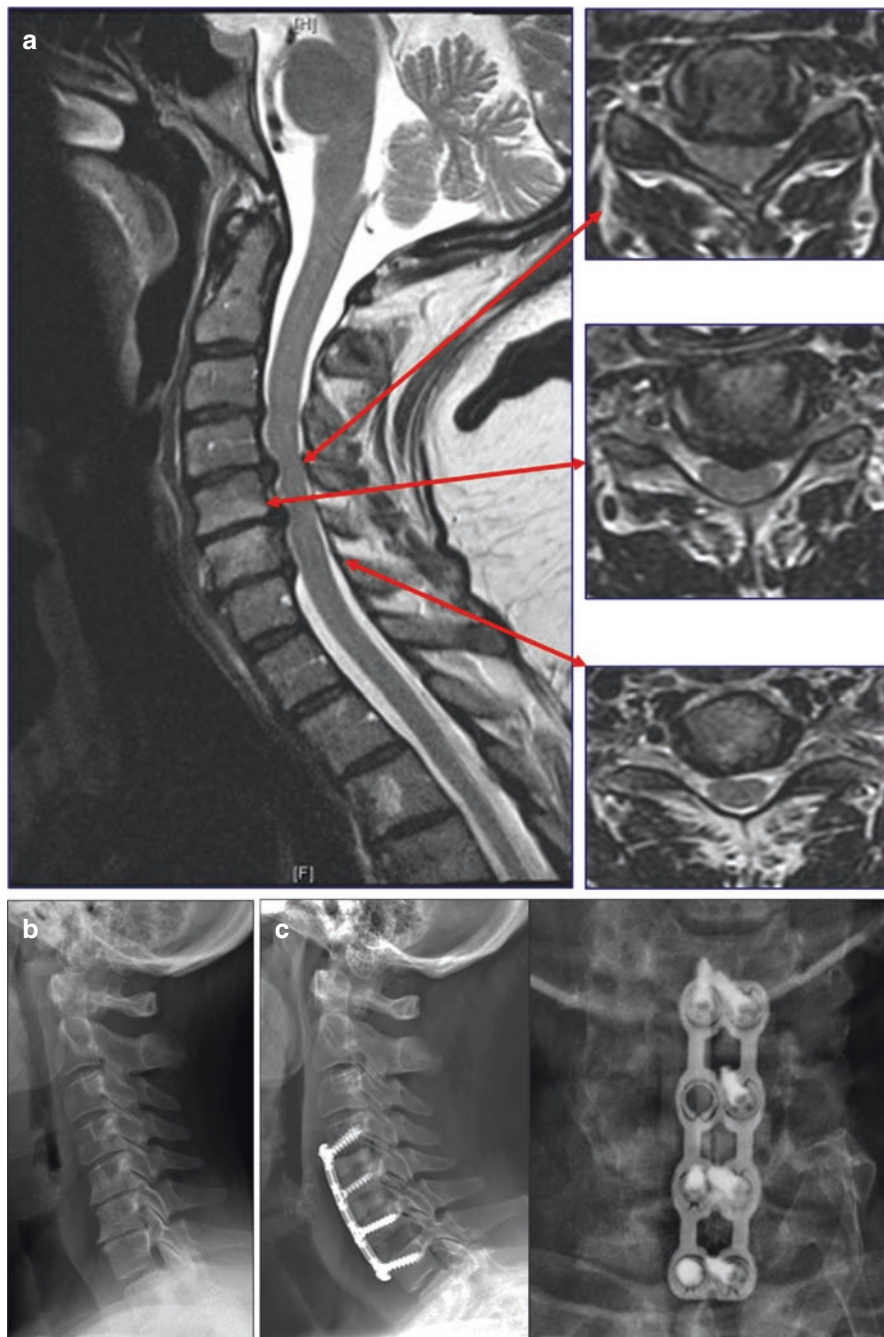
Hemi-corpectomy-discectomy (a) the preoperative MRI demonstrating multilevel cervical disease at C4-C5, C5-C6, and C6-C7. (b) and (c) Show the pre-op and post-op radiographs, respectively
